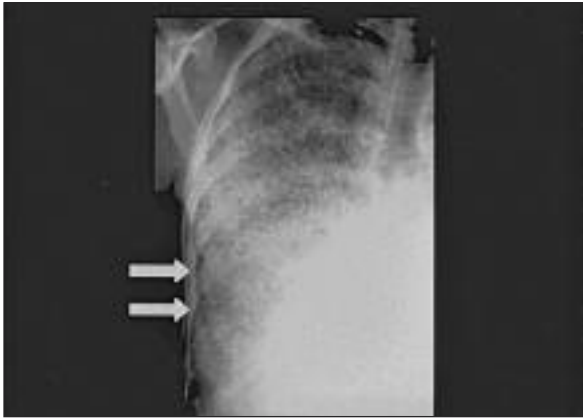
Chest radiograph of right hemithorax shows “sandstorm” lung and obscured cardiac silhouette with black pleural line (arrowheads) between ribs and lung parenchyma.
